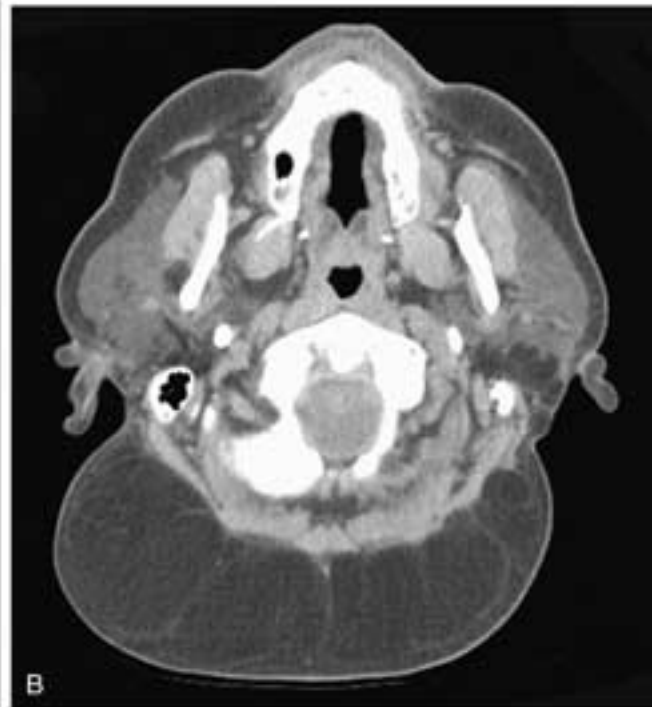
Axial CT scans (A and B) show multiple discrete fatty masses in the subcutaneous tissues of the back. Axial T1-weighted MR image (C) shows the well-delineated fatty collections in the posterior neck. This patient had Madelung's disease.
